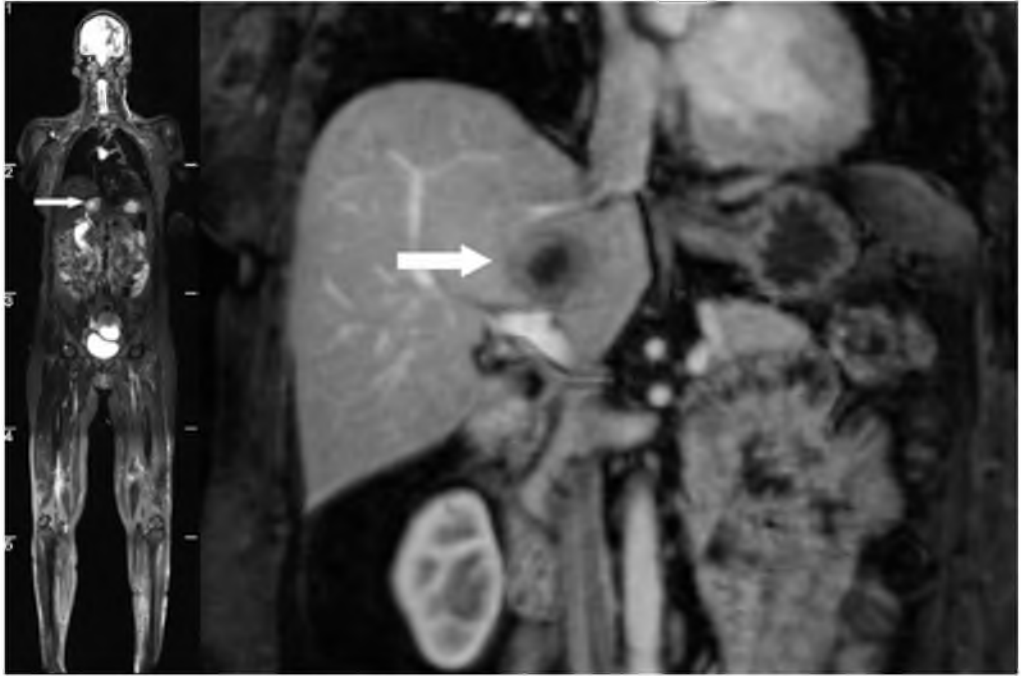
Images of a 47 year old woman, presenting with a T4 ILC. She underwent whole body MRI to screen for distant metastases. The whole body STIR acquisition (left) and the post contrast (15 ml Gd-DOTA) T1 weighted VIBE acquisition (right) show a large metastasis central in the liver, with central necrosis. The patient underwent neoadjuvant chemotherapy, to which she responded very well, 6 months later the liver metastasis was no longer visible and the primary tumor was surgically removed.
